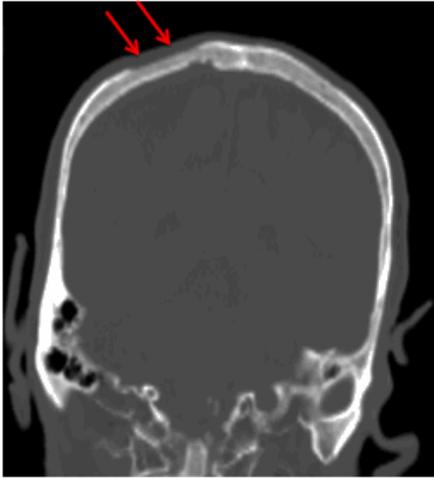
CT Coronal view bone window. Parietal osteodystrophy case. Focal right parietal bone thinning and erosion of outer table (Red arrows)
